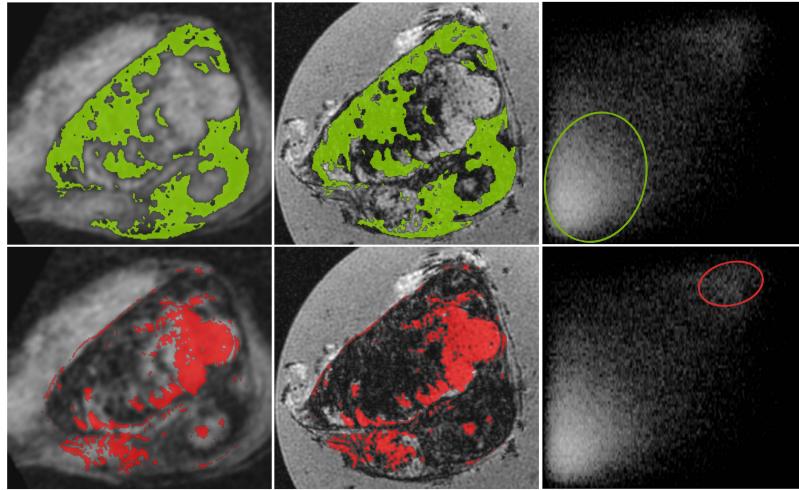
The joint histogram distribution (third column) of co-registered *in vivo* 3D-T2*W MRI (first column-fixed image) and *ex vivo* 3D-T2*W MRI (second column), referred to as ex2in. Green/red overlay in the images corresponds to the ellipses in the joint histogram distribution matching with not viable (green) and viable (red) tissue.
